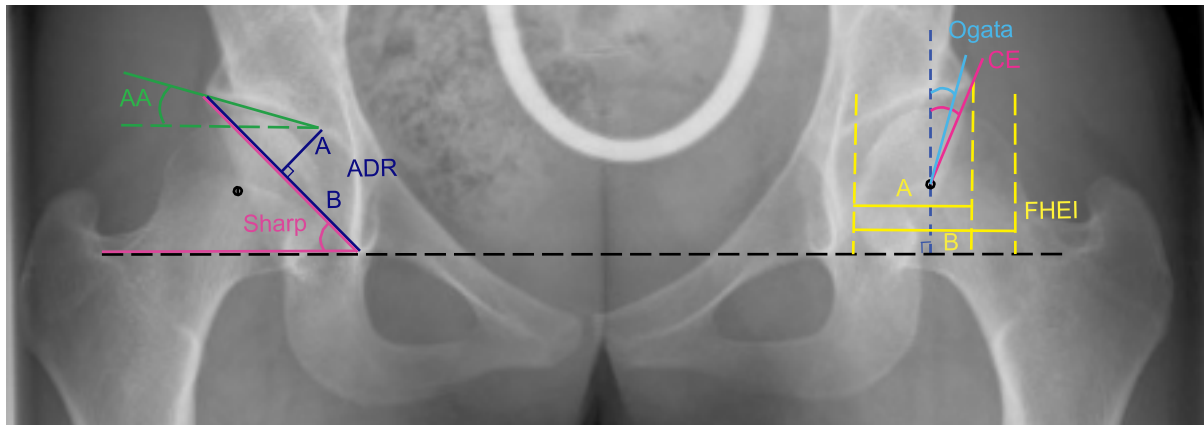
Common radiographic measurements for acetabular dysplasia at skeletal maturity.
